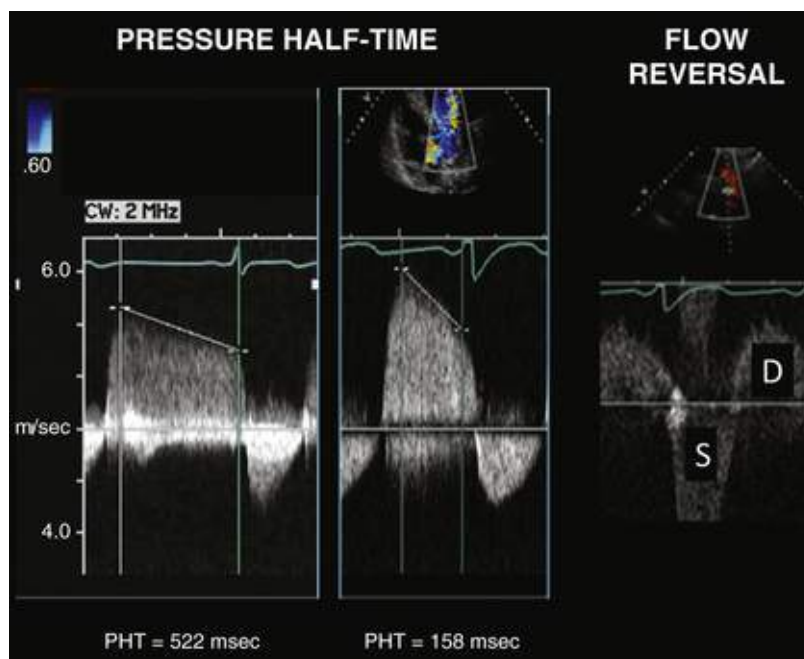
Doppler methods of quantitating aortic regurgitation (AR). A pressure half-time (PHT) greater than 500 milliseconds suggests mild AR, 200 to 500 milliseconds suggests moderate AR, and less than 200 milliseconds suggests severe AR. Holodiastolic flow reversal in the descending thoracic aorta, as shown here, is consistent with at least moderate AR. S, Systole; D, diastole.
